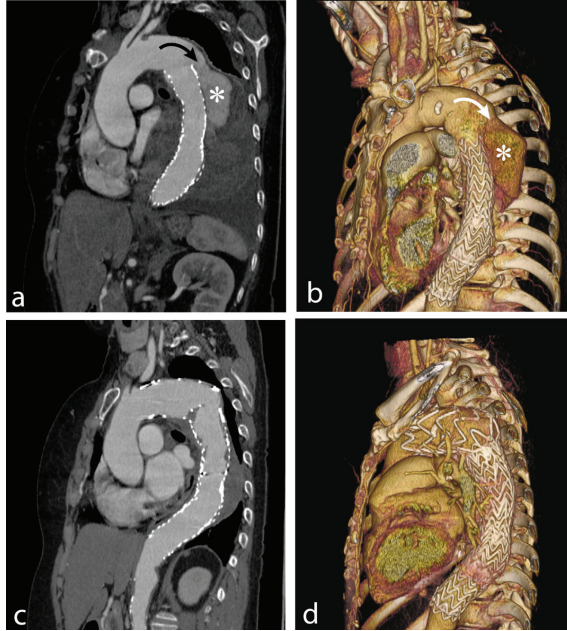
Type I endoleak. Sagittal oblique CT image (a) and 3D volume rendering (b) of post TEVAR of descending aortic aneurysm show leakage of contrast media at proximal end of the stent graft (curved arrow) to aneurysmal sac (*), which is tubular shaped adjacent to supero-posterior aspect of the stent graft. After second session of TEVAR implantation, the sagittal oblique CT image (c) and 3D volume rendering (d) shows no residual endoleak from the proximal end of the stent graft
